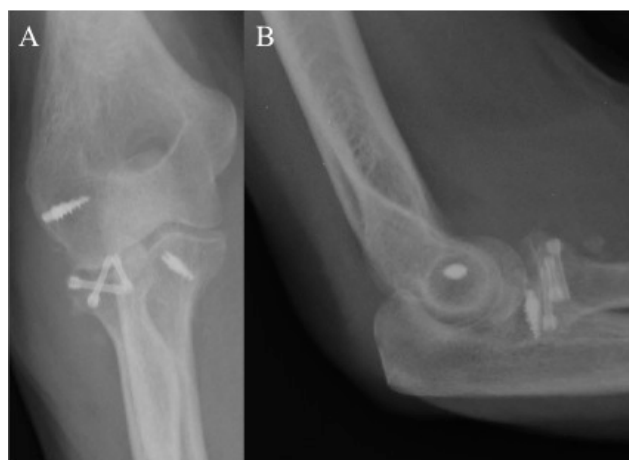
Anteroposterior (A) and lateral (B) postoperative radiographs of the case shown in Figure 1. Radial head was fixated with three low-profile headless compression screws and the both the coronoid process and the collateral ligament were fixated with suture anchors.
